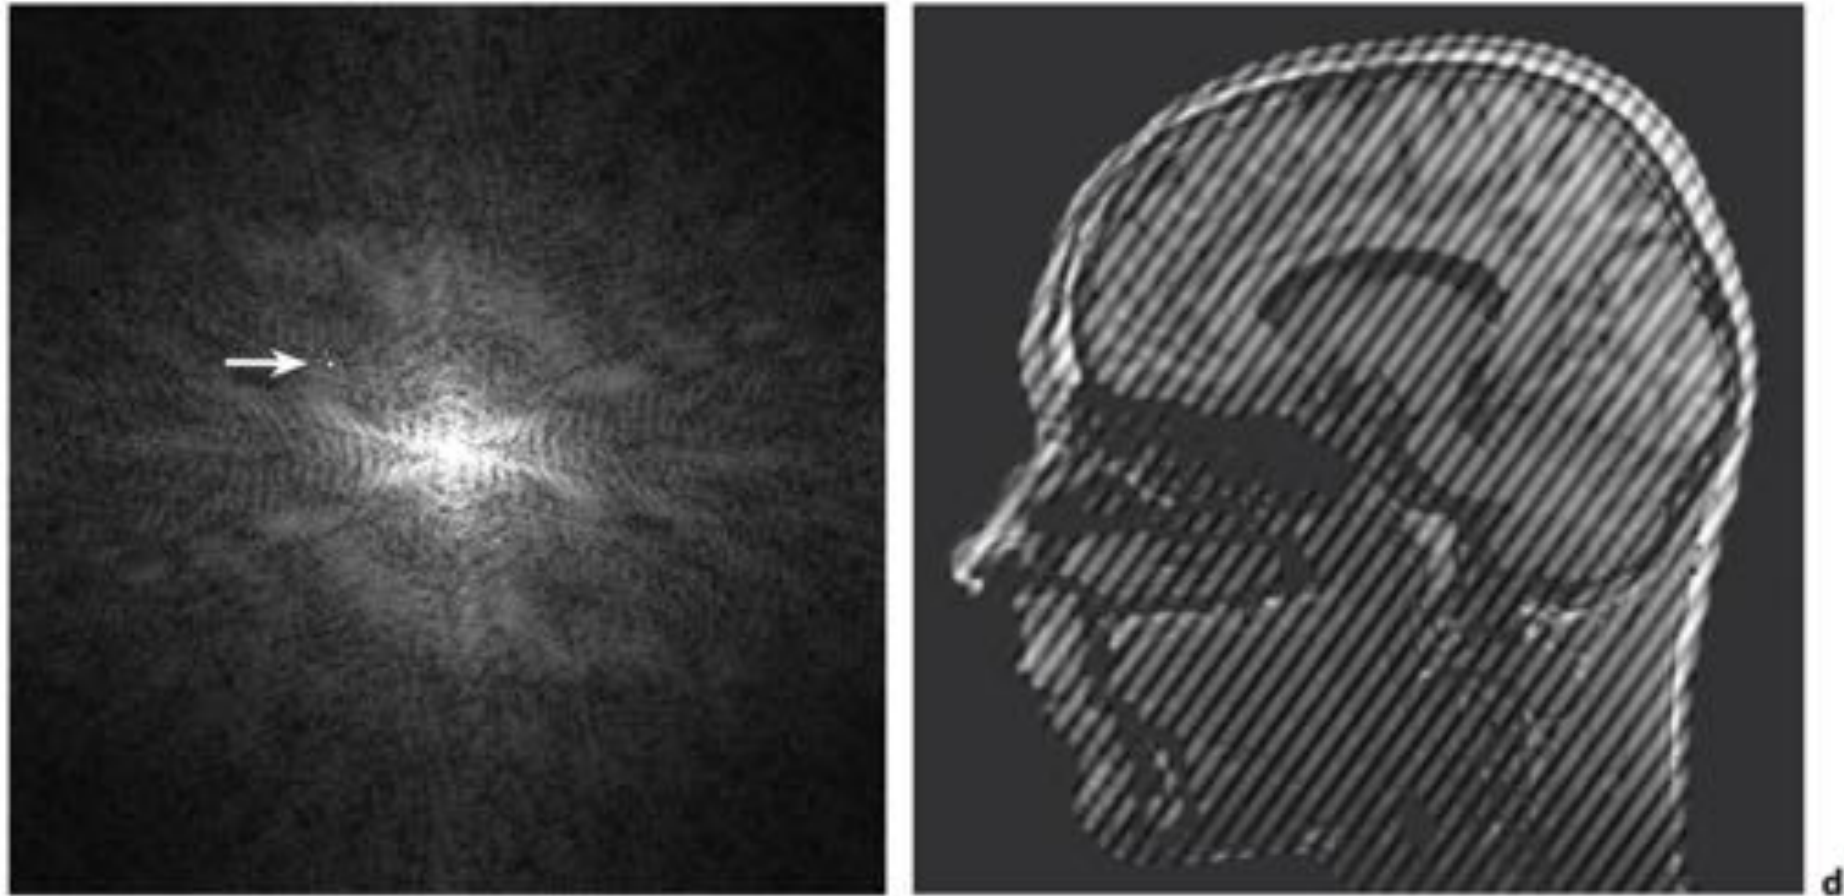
a Raw data after adding a single point with artificially increased intensity (*arrow*) and b corresponding reconstructed MR image. The image is affected from artefacts extending over the complete field of view.
